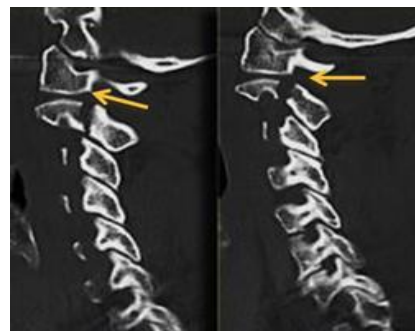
CT of the Hangman's fracture - type I
